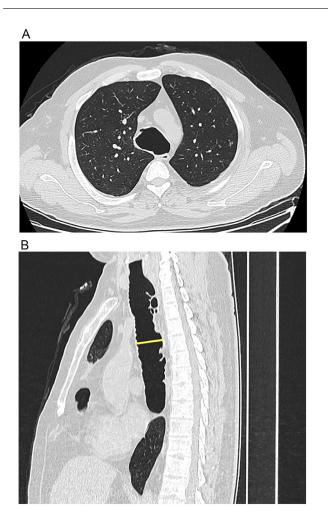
A 55-year-old male patient with Mounier-Kuhn syndrome. Chest computed tomography in parenchymal window showing dilated trachea measuring 45 mm (A) and 32 mm (B) in the transverse and sagittal planes respectively, with an irregular wall.
